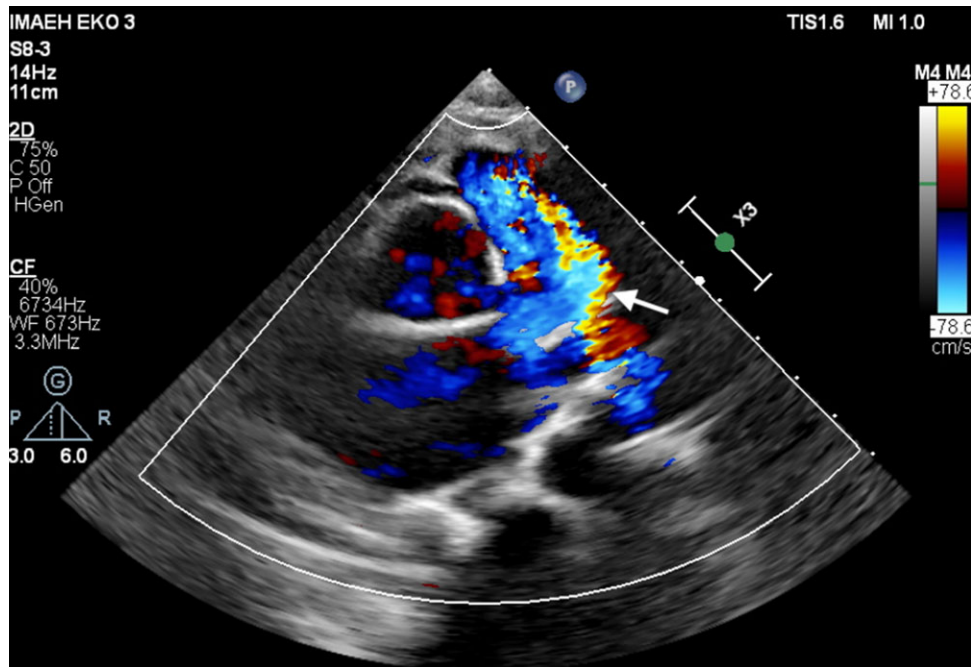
The color Doppler echocardiography image shows the flow of blood from the aortic root to the pulmonary artery and the right coronary artery flow jet directed into the pulmonary artery.
